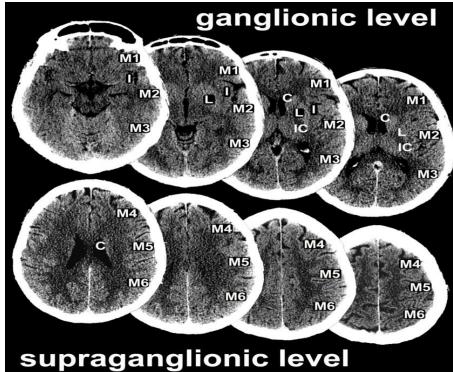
ASPECTS study form
